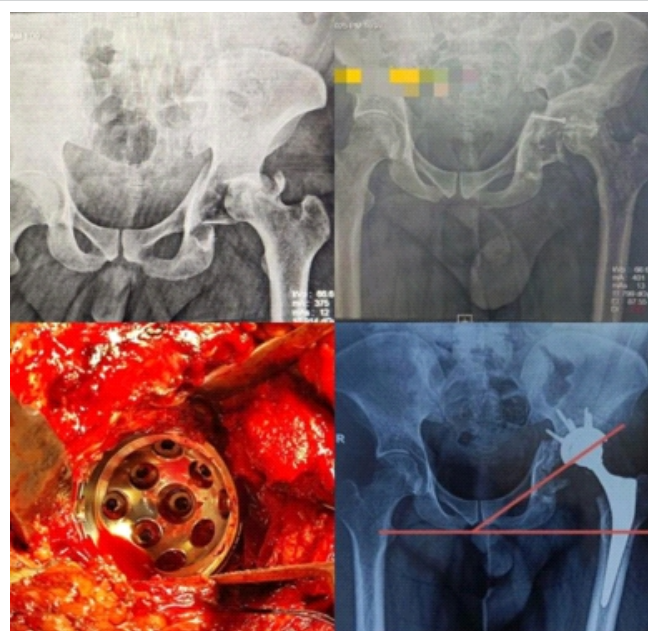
Case 3: Pre-operative, intraoperative photos and post-operative X-rays.
